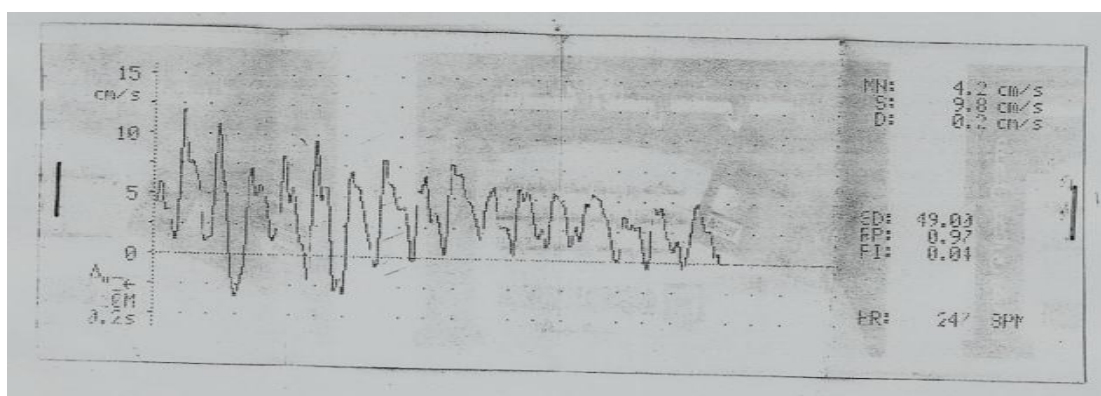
Doppler ultrasound record of testicular blood flow in colchicine induced infertility group.
